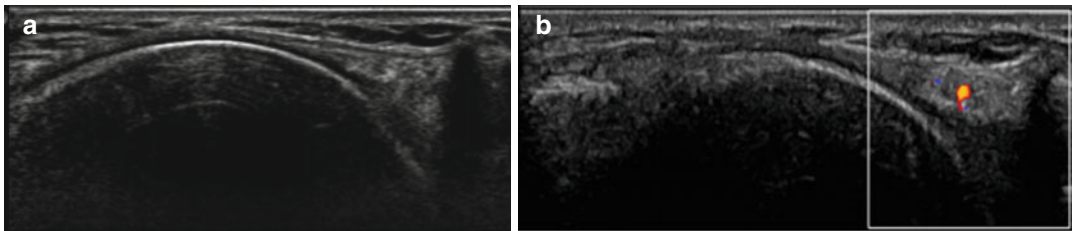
(a) Anteromedial meniscus (b) Vascular Doppler technology
